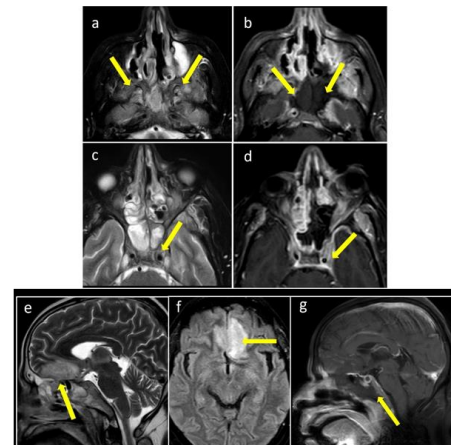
(a-d) Axial T2-FS and T1 Post contrast images demonstrate: bilateral pterygopalatine fossa involvement and Central SBO with osteonecrosis (a,b), left cavernous sinus involvement with left cavernous ICA wall thickening(c ,d).(e-g) Sagittal T2W, Axial FLAIR and Sagittal T1 post contrast images in the same patient: Contiguous extension of disease from ethmoid sinus across the cribriform plate to the frontal lobes (e,f) and necrosis of the clivus presenting as complete loss of enhancement (g).
